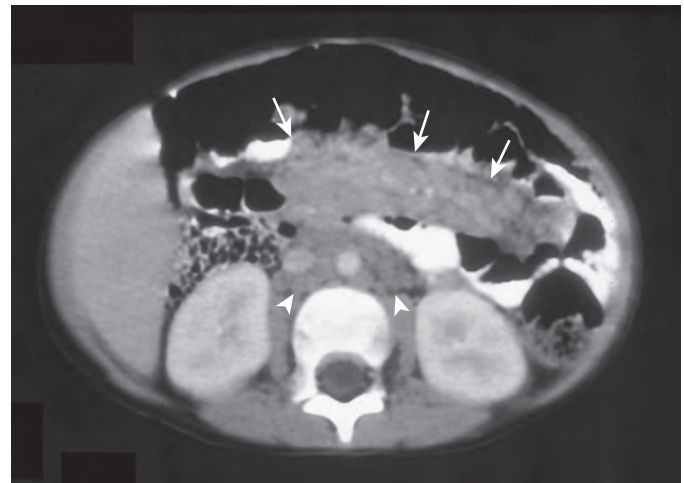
Lymphoma. Transverse CT image of 3-year-old child with lymphoma demonstrates a soft tissue nodal mass along the mesentery (arrows) and para-aortic and aortocaval retroperitoneal lymphadenopathy (arrowheads).
